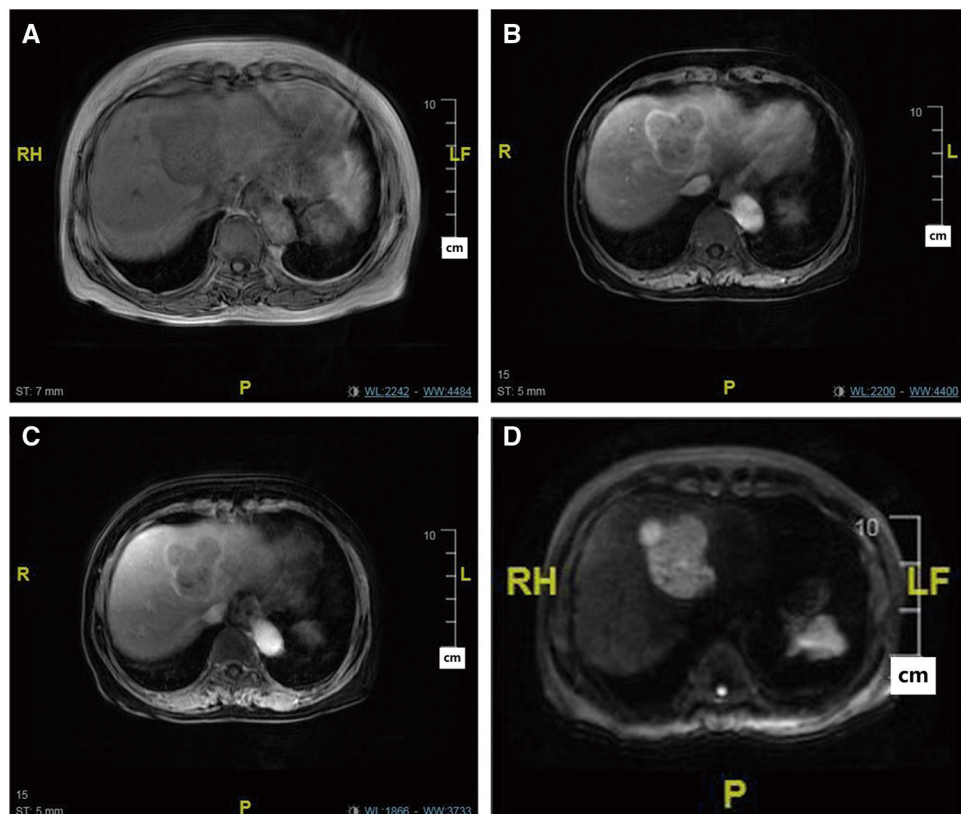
Combined hepatocellular cholangiocarcinoma in a 74-year-old woman. (A) T1-weighted image shows a hypointense tumor. Contrast-enhanced (B) arterial phase image shows rim hyperenhancement with arterial peritumoral enhancement; (C) delayed image shows a non-washout (depressive) enhancement pattern with enhancing capsule. (D) Diffusion-weighted image shows peripheral hyperintensity and central hypointensity.
